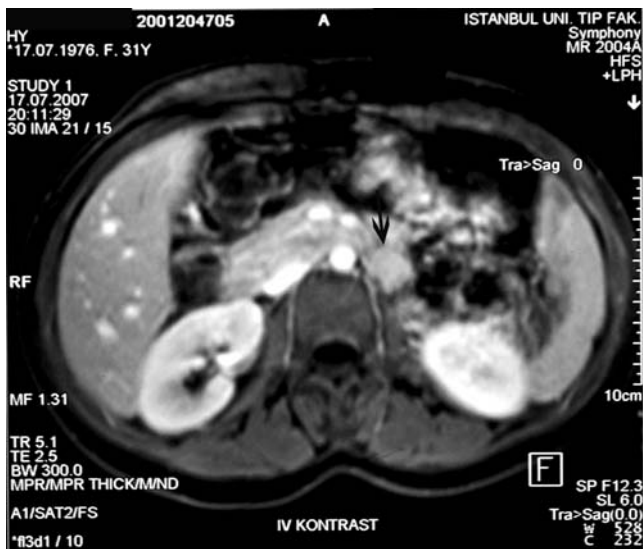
Abdominal magnetic resonance imaging of the patient indicating a left paramedian mass measuring 2 cm in diameter (with contrast)
